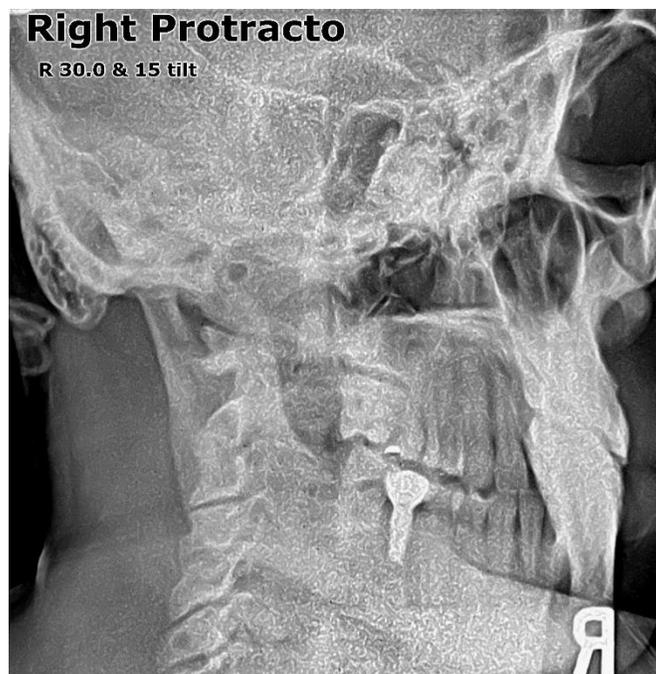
Right Protracto radiograph showing the ASR-PIL misalignment
